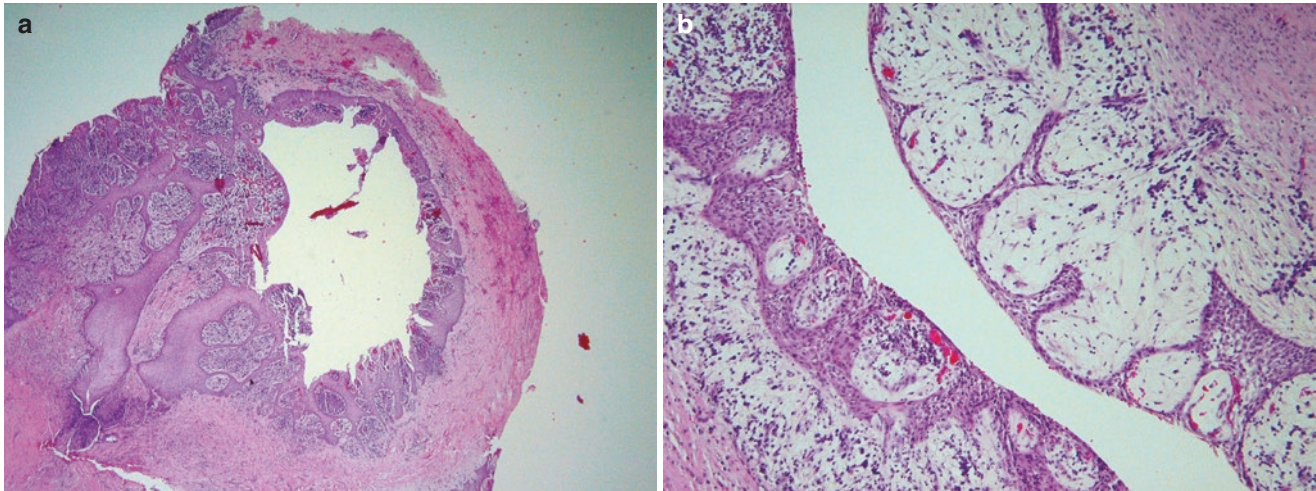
Periapical (radicular) cyst. (a) The cyst is lined by stratified squamous epithelium with varying thickness and frequently exhibits degenerative changes due to inflammation in the wall. (b) The lining
